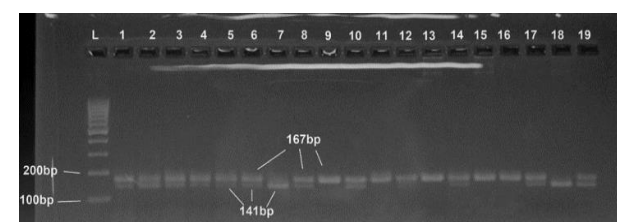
genotyping of rs352140 polymorphism by PCR-RFLP technique, lane L 100bp DNA ladder; lanes 9,11,12,13,15, and 16 TT genotype; Lanes 1,2,3,4,5,6,8,10,14,17 and19 CT genotype; lanes 7and 18and CC genotype.
